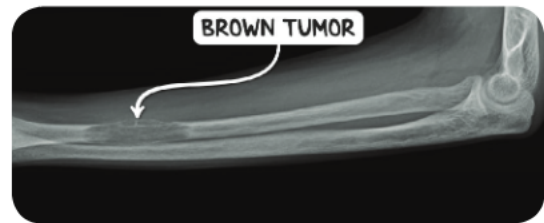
A X-ray image of the forearm demonstrating a brown tumor of the distal radius in an individual with hyperparathyroidism.
